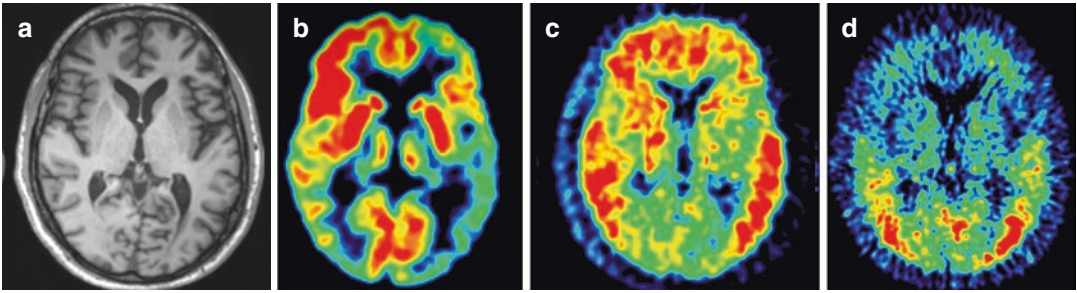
PET images from a 60 y/o M with fatigue, difficulty concentrating, memory, and mood disorder, diagnosed with AD. (a) structural MRI, (b) $[^{18}\text{F}]\text{FDG}$ PET, (c) $[^{11}\text{C}]\text{PiB}$ PET, and (d) $[^{18}\text{F}]\text{AV-1451}$ PET. The MRI scan shows mild atrophy. The $[^{18}\text{F}]\text{FDG}$ scan shows abnormally decreased uptake in the posterior brain regions. The degree of uptake is asymmetric, much lower
